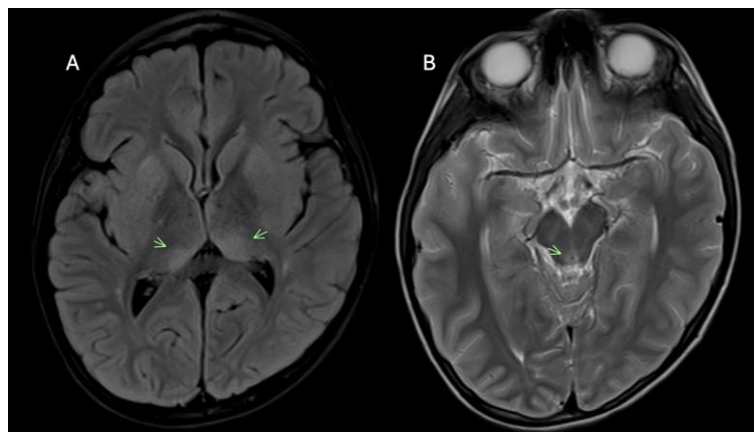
Wernicke encephalopathy demonstrating classic anatomical involvement. (A) Axial FLAIR image reveals bilateral symmetric hyperintensity within the medial thalami, a hallmark location for thiamine deficiency. (B) Axial T2-weighted image demonstrates a characteristic periaqueductal gray matter signal abnormality. The involvement of these symmetric midline structures, particularly the combination of medial thalamic and periaqueductal changes, is pathognomonic for Wernicke encephalopathy.
